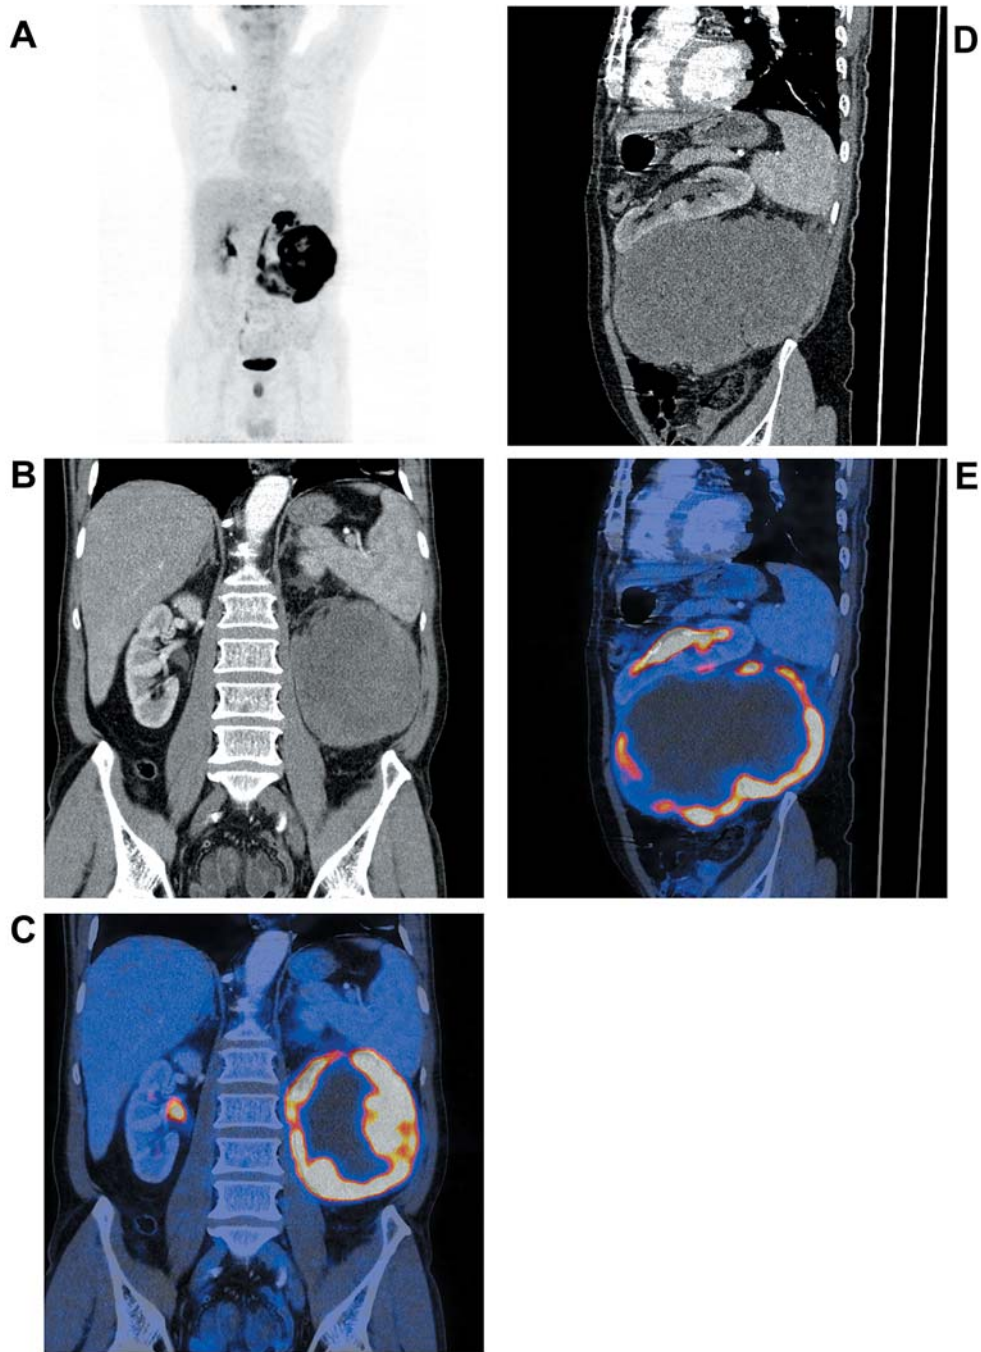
patient dying after one month after nephrectomy due to the massive intraabdominal spread of tumor, conventional renal cell carcinoma with sarcomatoid transformation, extreme level accumulation of FDG exceeding  $\text{SUV}_{\text{max}} 20$ . A – whole body MIP PET; B, D – CT images, C, E – PET/CT fusions – levels of displayed  $\text{SUV}_{\text{max}}$  0-10.
